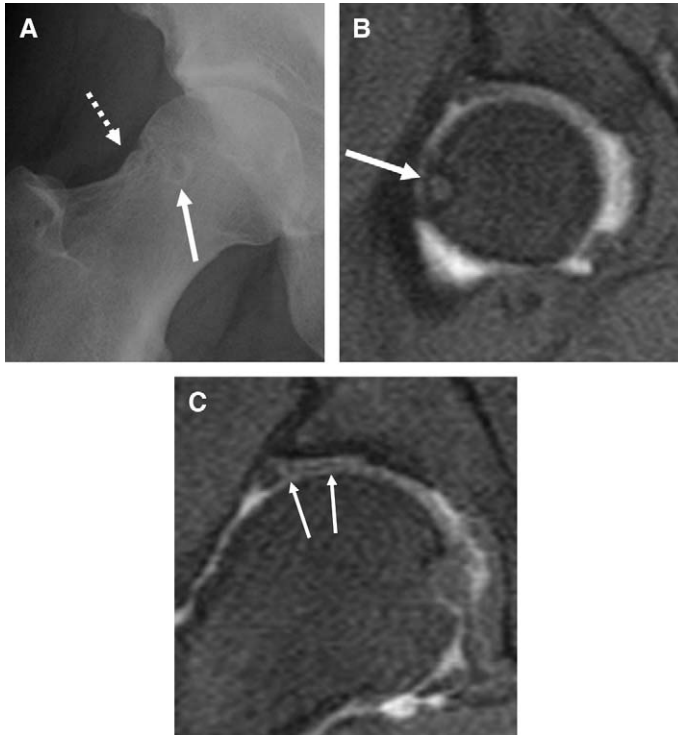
Synovial herniation pits (fibrocystic changes). (A) Anteroposterior radiograph showing a lateral femoral neck “bump” (*dotted arrow*), indicating a cam type FAI. There is also a rounded lucency located in the anterolateral femoral neck (*solid arrow*), an appearance known as a synovial herniation pit. The coronal view on the MR arthrogram is located far anteriorly (B) and shows the herniation pit to be low in signal (*arrow*). This suggests the fibrous tissue within the pit; they may also contain high signal fluid. These fibrocystic changes are seen more frequently in hips with cam-type FAI than in the asymptomatic patient population. (C) Coronal view in the mid portion of the joint, shows irregularity of the cartilage and labrum with imbibition of contrast (*arrows*); this represents injury to these soft tissue structures.
